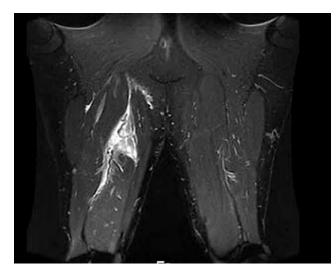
Post-Injury MRI
